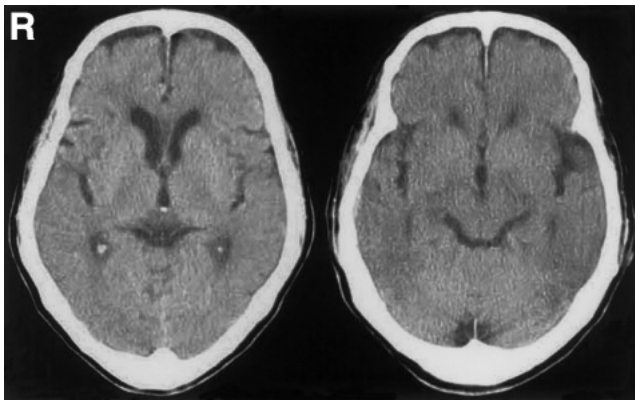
Initial computed tomography scans showing no signs of ischemic change.
